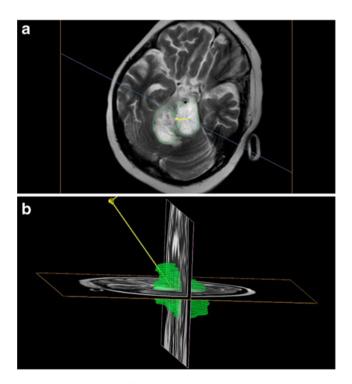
Axial (a) and multi-planar (b) T2-weighted MR images on completion of the final infusion. Hyperintense signal change was used as a measure of infusate distribution within the tumor (*shown in green*). The volume of T2 signal change represented 95 % of the targeted tumor volume
